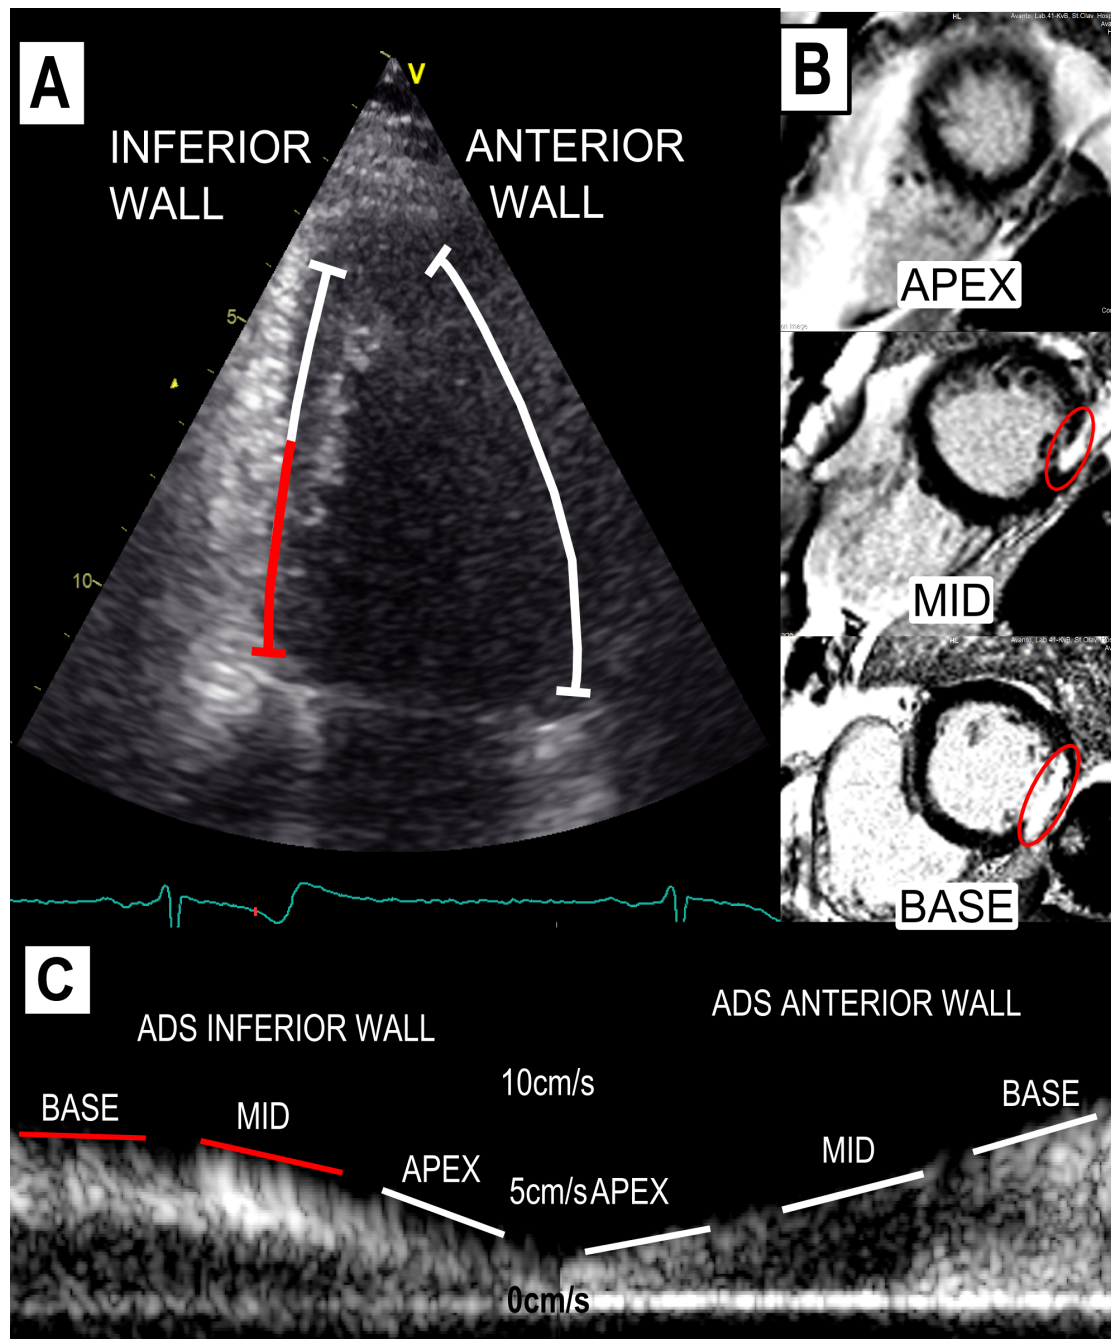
Anatomic Doppler Spectrum from anterior and inferior wall in a patient with an inferior wall infarction: A: B-mode image and anatomical curve forming the basis for Anatomic Doppler Spectrum. B: Late gadolinium-enhanced MRI from the same patient. The infarcted area is visible as enhanced scar in the basal and midventricular inferior wall (demarcated with red ring). C: The Anatomic Doppler Spectrum shows nearly the same slope in all anterior segments, despite low signal (lung or bone shadow). In the inferior wall there is almost no slope in the basal segment, reduced slope in the middle, and normal slope in the apical segment. This corresponds with the scar distribution seen on the late gadolinium-enhanced MRI to the right.
